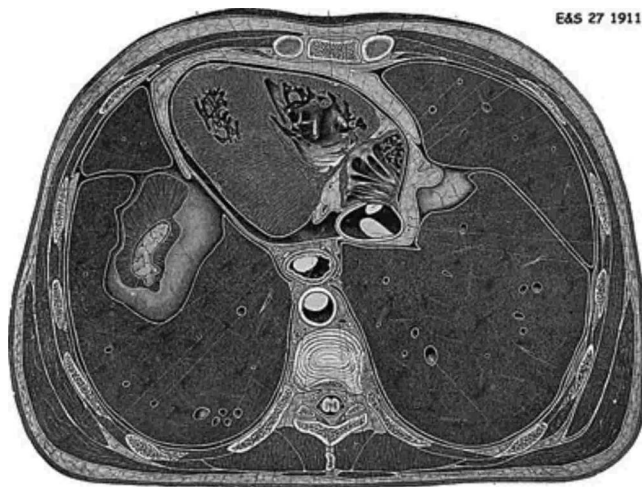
Page from anatomical cross section atlas often used for pre-CT treatment planning (Eycleshymer and Schoemaker).
